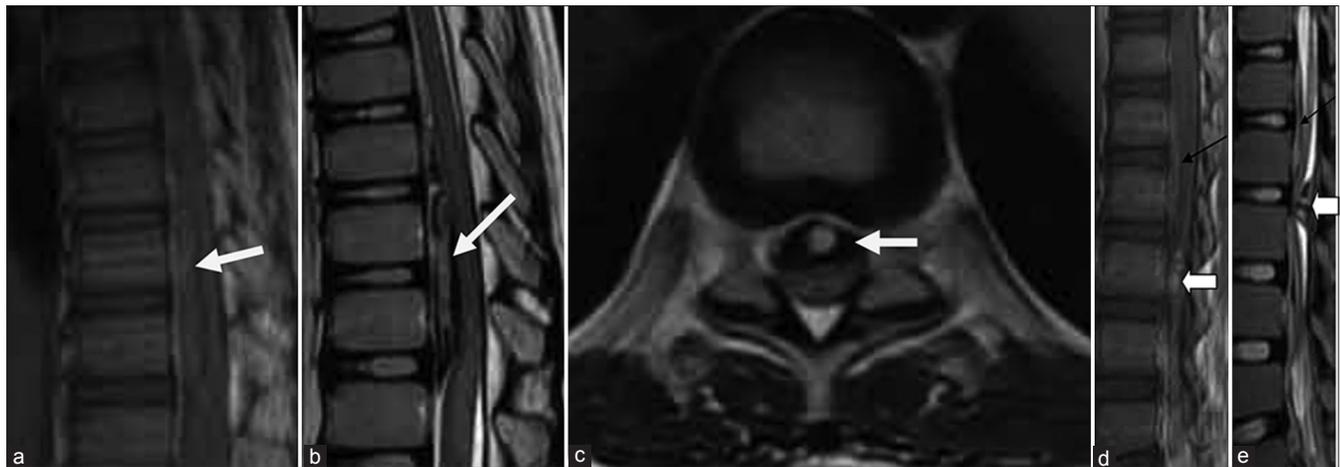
Magnetic resonance imaging (MRI) of a 16-year-old male presenting a spontaneous hyperacute subdural hematoma at T9 to T11 level. (a) Sagittal T1WI demonstrates an isointense collection (arrow) in the anterior subdural space with posterior compression of the spinal cord. (b) Sagittal T2WI demonstrates a hyperintense collection (arrow) with hypointense rim, in the anterior subdural space with posterior compression of spinal cord. (c) MRI of a 16 year male presenting a spontaneous hyperacute subdural hematoma at T10 level. Axial T2WI demonstrates a hyperintense collection (arrow) with hypointense rim, in the anterior subdural space with posterior compression of spinal cord. (d) Sagittal T1WI demonstrate a spontaneous hyperacute epidural hematoma at L1-2 level showing a biconvex, isointense collection (arrow) in the anterior epidural space with subtle posterior compression of spinal cord and early subacute subdural hematoma at L3 level (white block arrow). (e) Sagittal T2WI demonstrate a spontaneous hyperacute epidural hematoma at L1-2 level showing a biconvex, hyperintense collection with hypointense rim (arrow) in the anterior epidural space with subtle posterior compression of spinal cord and early subacute subdural hematoma at L3 level (white block arrow) showing hypo to hyperintense collection
